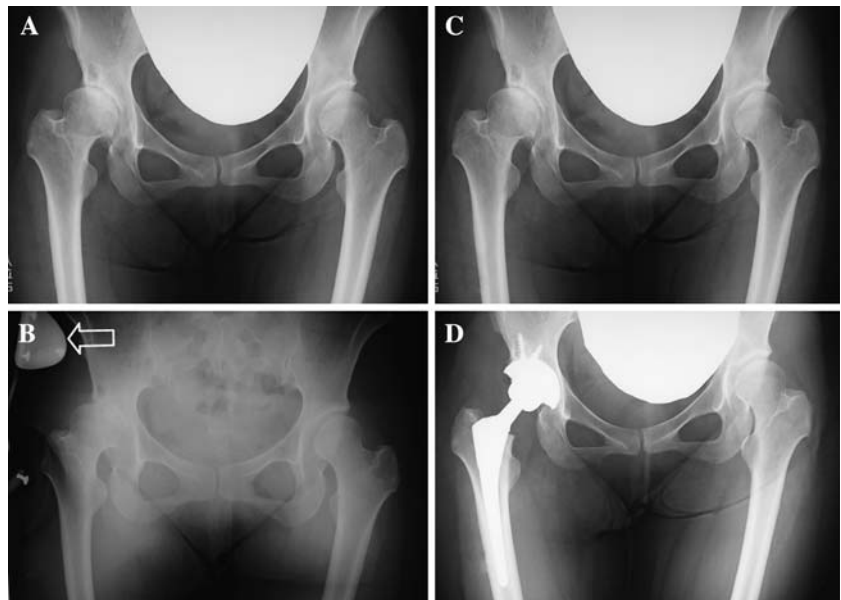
Radiograph showing grade III of OA in case 12 (a). WISH-type S-form hip brace was applied for her left side (arrow), then improved her hip function scores (b)
